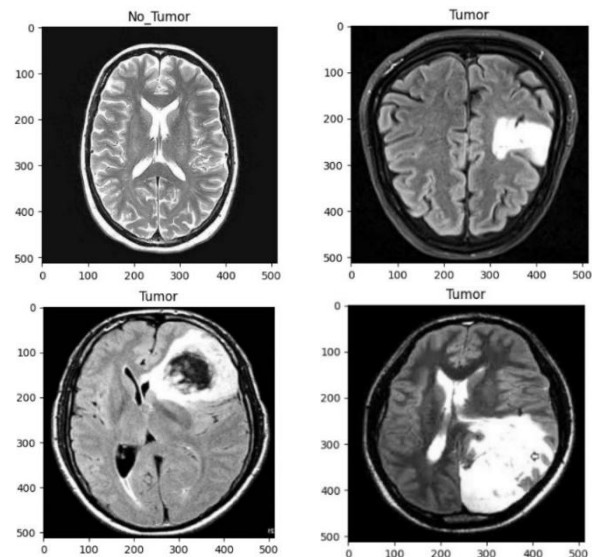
MRI images with tumour and no tumour from Br35H database
